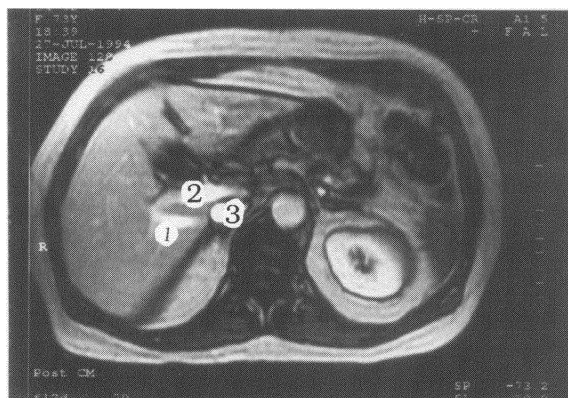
Magnetic resonance image of upper abdomen pre-operation (transverse plane). 1: inferior right hepatic vein, 2: portal vein, 3: inferior vena cava.
